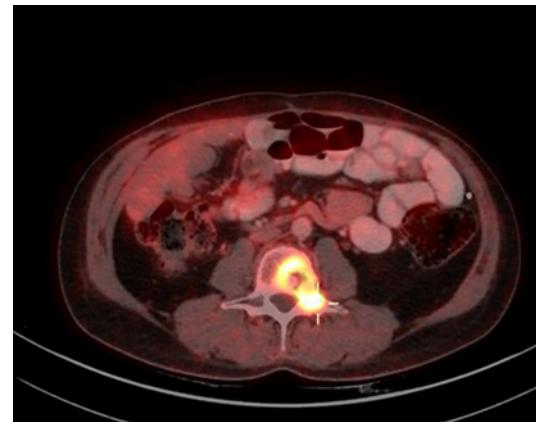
September 2021, PET-CT axial view, L3.
